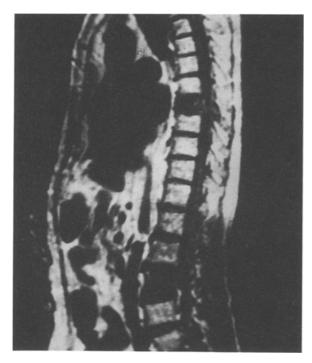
MRI (using the body coil) showing two areas of vertebral involvement. One with ESCC at T8 and another asymptomatic L3 metastasis.
